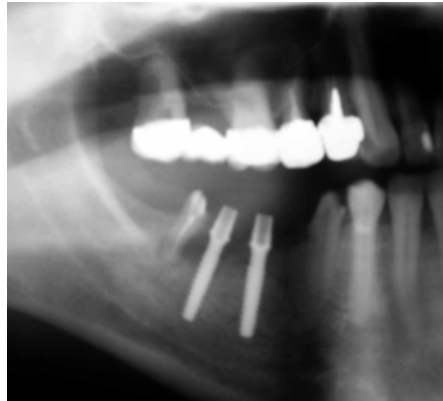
X-ray control of the position of implants inserted to alveolar split
